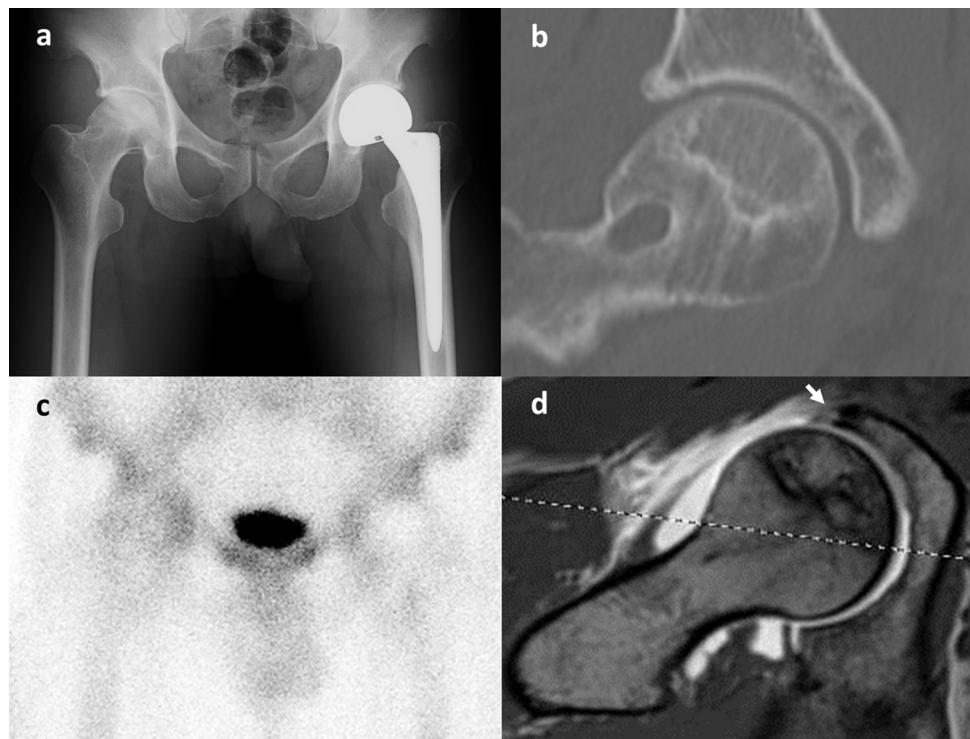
(a) Anteroposterior radiograph obtained just before the arthroscopic surgery. Sclerotic band and herniation pit was more obvious than 4 years ago. (b) Multiplanar reconstruction of computed tomographic image showing no obvious collapse of the femoral head. (c) Bone scintigraphy demonstrated cold in hot pattern as seen in primary osteonecrosis and no increased uptake due to collapse. (d) Arthro-MRI showing intensity change of anterolateral part of the labrum which indicates labral tear (white arrow).
